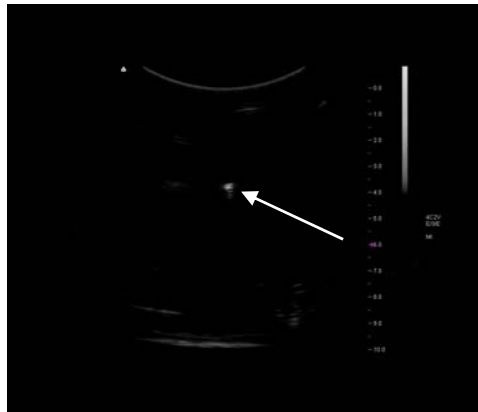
Ultrasound image (with needle tip at bright spot indicated by arrow)
